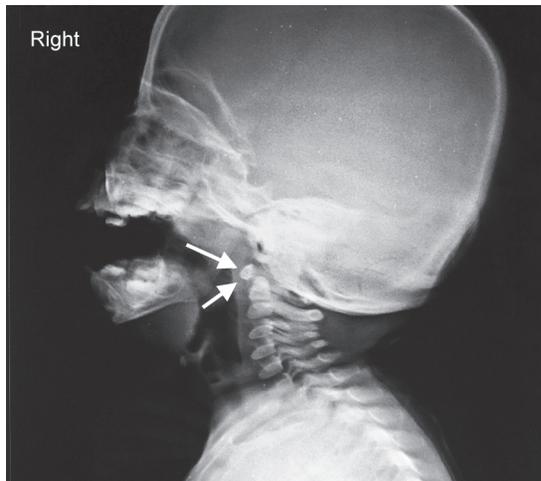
X-ray nasopharynx showing a spherical radio-opaque shadow in the region of the nasopharynx (white arrows)
